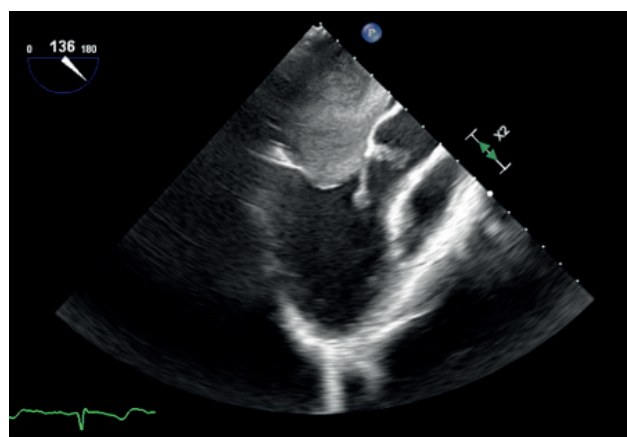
Intraoperative transoesophageal echocardiogram showing left atrial mass abutting into left ventricle.
